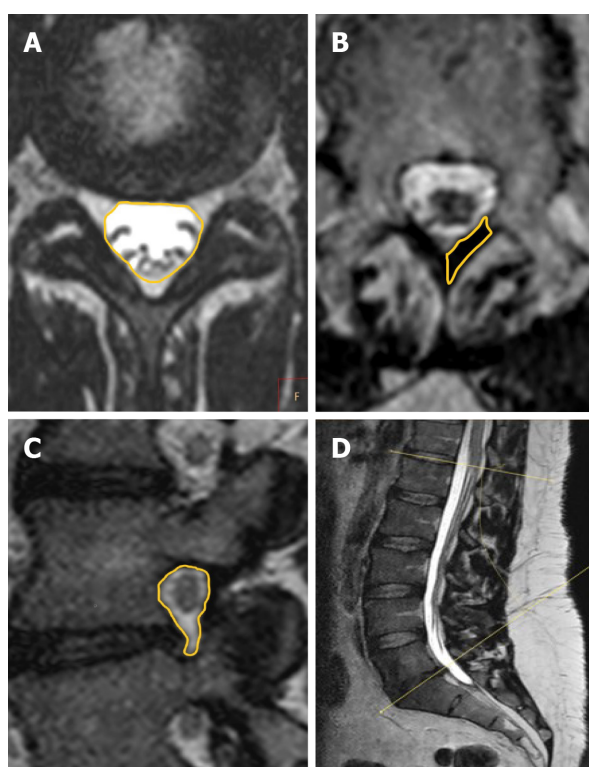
Specific measurements of (A) the cross-section area of the dural sac on transverse magnetic resonance imaging, (B) the cross-section area of the ligamentum flavum, (C) the sagittal cross-section area of vertebral foramina and (D) the lumbosacral angles between L1 and S1.
